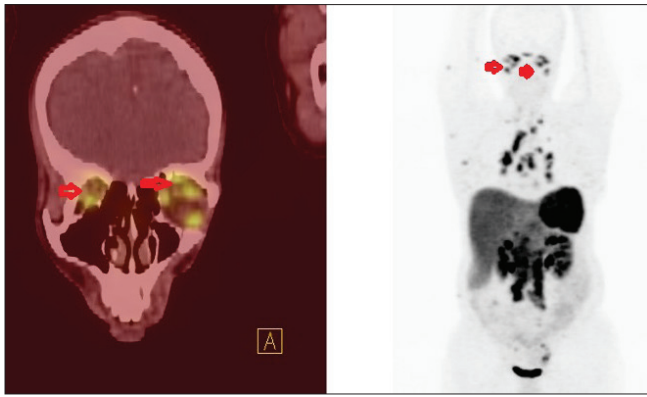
Whole body gallium-68 DOTANOC-PET/CT coronal fused and maximum intensity projection image showing intense uptake in the bilateral extraocular soft tissue muscle metastasis (arrows). Also, multiple mediastinal and retroperitoneal lymphnodes noted
